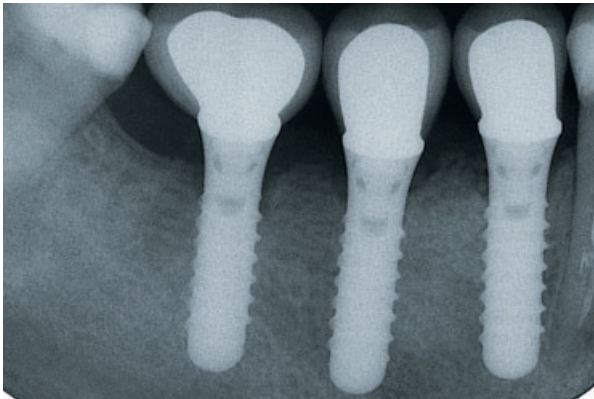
As confirmed by the follow-up radiograph, an increased (more molar-like) dimension has been given to the most distal restoration, despite the fact that a standard-sized implant had to be used for restricted bone volume reasons.
